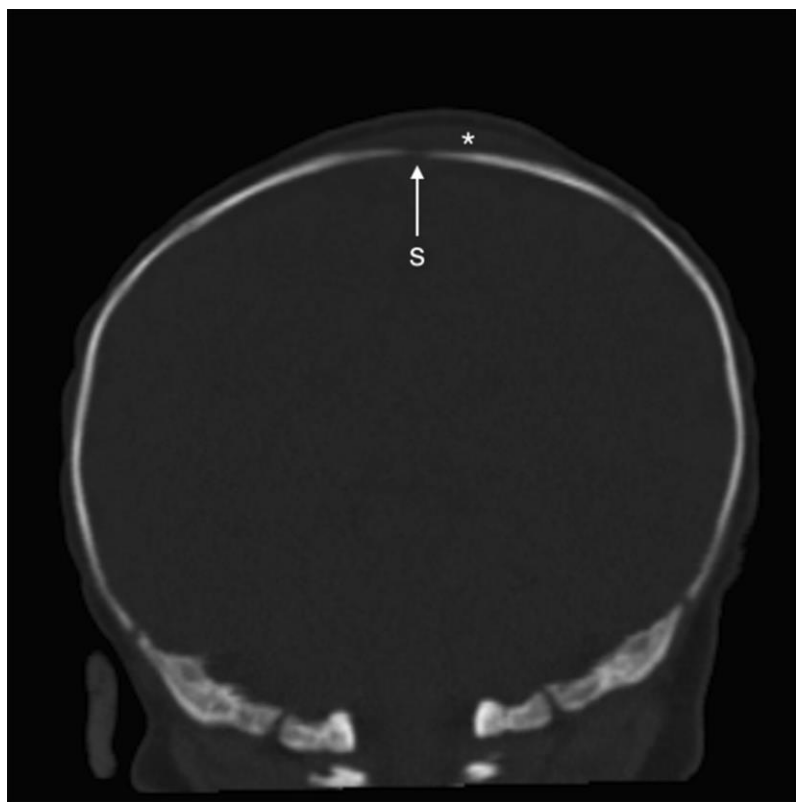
CT scan of the brain with subaponeurotic fluid collection (*) extending over the sagittal suture (s).⁵
